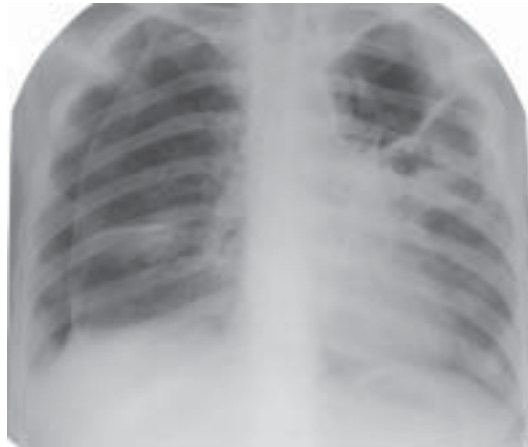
Right-side spontaneous pneumothorax. Fibrous-cavernous tuberculosis of the left lung. Observation roentgenogram.
